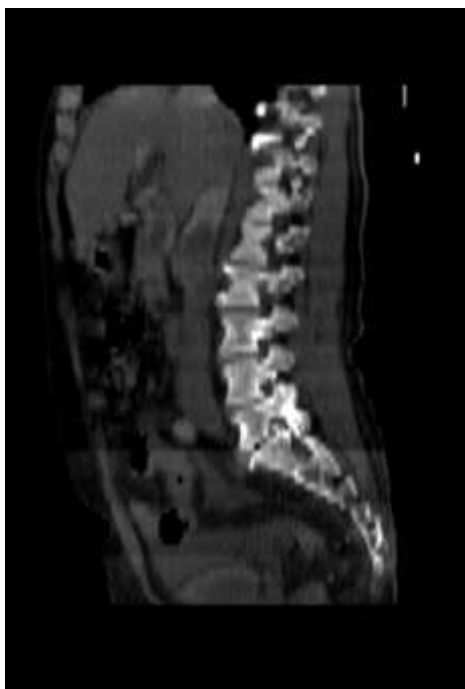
Sagittal contrast-enhanced CT reconstruction showing the longitudinal extent of IVC tumor thrombus.
